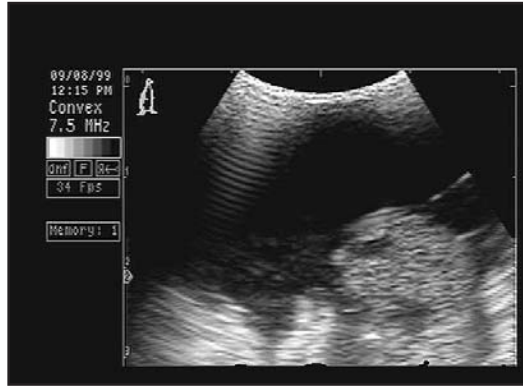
Coelomic ultrasound of the cockatiel hen from Fig 18.11. Note the coelomic fluid and soft tissue density. Laparotomy revealed an oviductal granuloma, and the hen recovered fully in response to salpingohysterectomy and antibiotic therapy.
